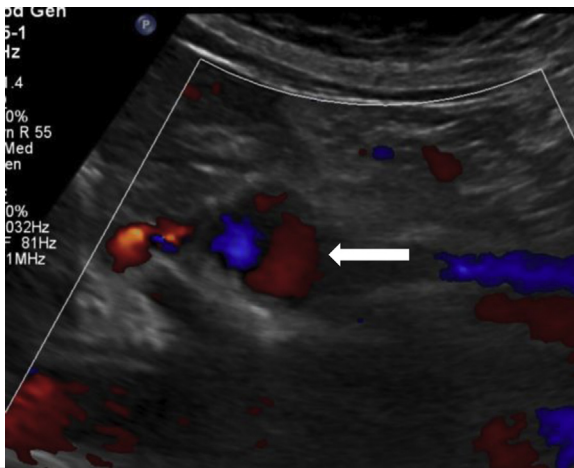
Duplex ultrasound scan depicting recanalized splenic artery aneurysm (arrow).
